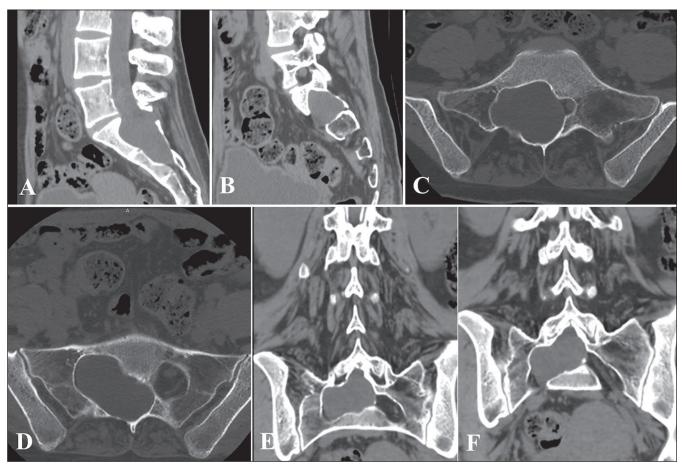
CT sagittal (A and B) axial (C and D) and coronal (E and F) images showing an isodense tumor with bony erosion and remodeling
